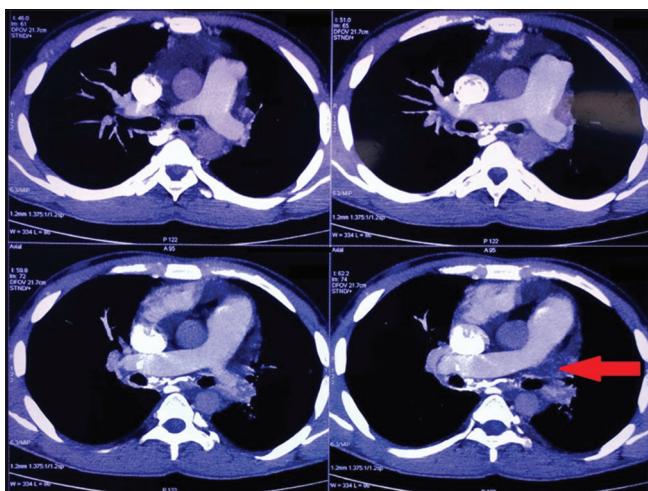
Computed tomography pulmonary angiogram image showing filling defect in the left pulmonary artery
